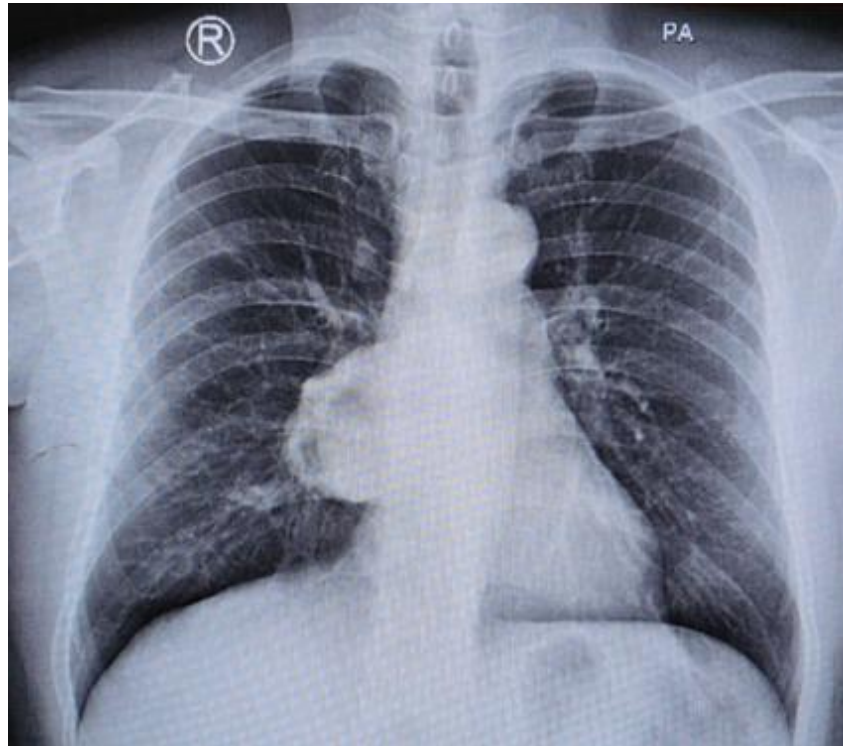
Patient's chest radiograph image
